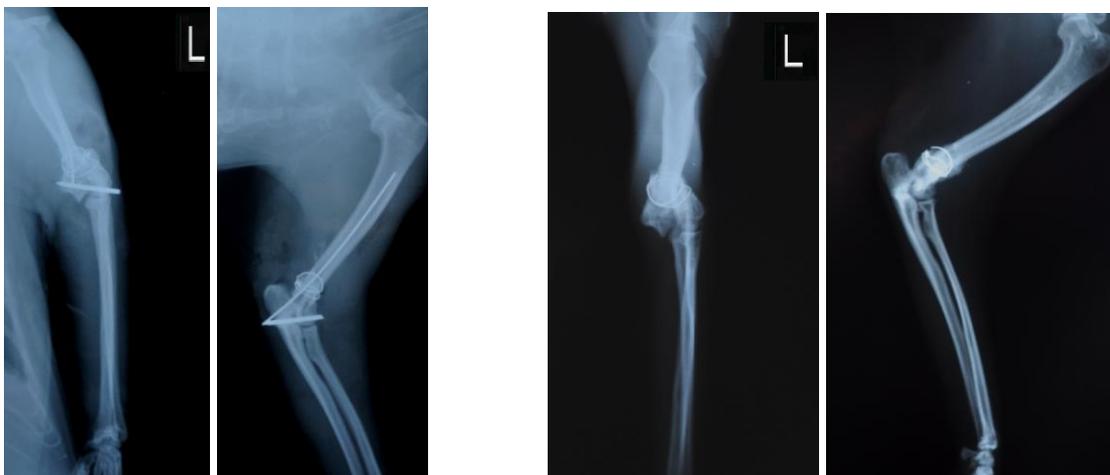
Preoperative and postoperative A/P and M/L radiographies on 21st day and after nail removal on the 45th day of Case no. 3
